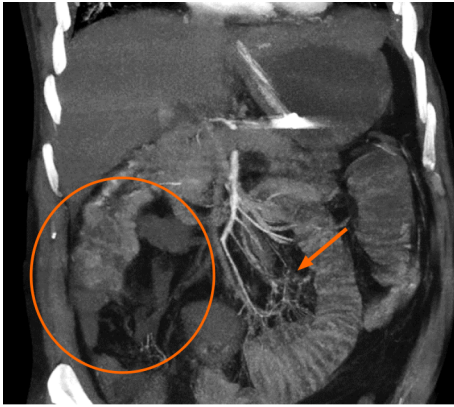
Acute mesenteric ischemia diagnosed on computed tomography mesenteric angiography performed in a critical patient with coronavirus disease 2019 presenting with severe abdominal pain. The coronal maximum intensity projection image reveals a lack of opacification of the right sided branches of the superior mesenteric artery (SMA), namely, the ileo-colic and right colic branches (orange circle). The distal branches of the SMA also appear hypoperfused (orange arrow). Imaging features are consistent with SMA thrombosis.
